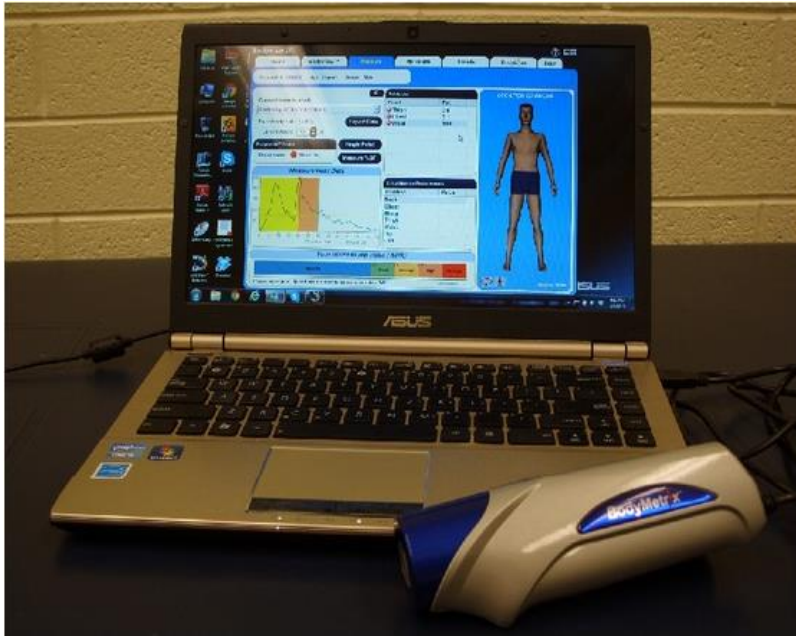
BodyMetrix ultrasound
